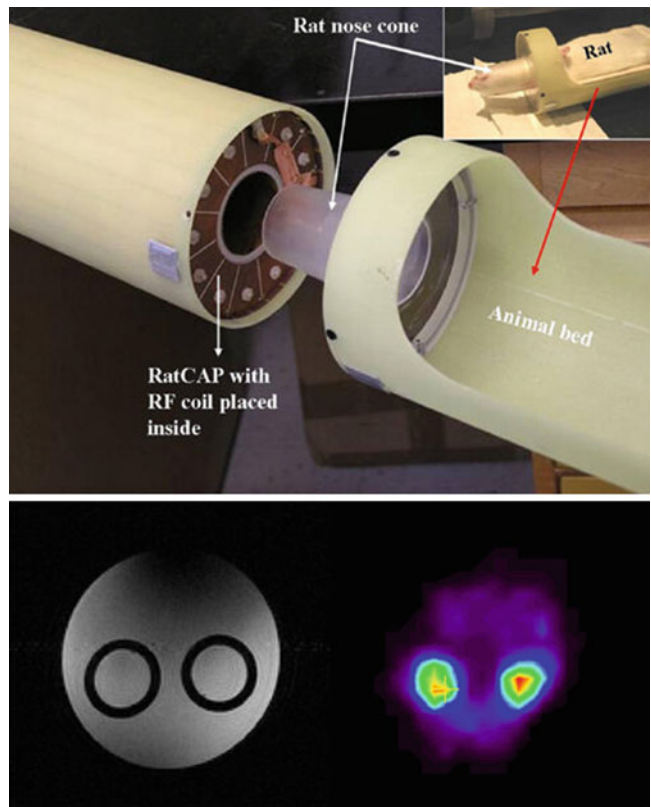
Simultaneously acquired PET/MR images using APD-based MRI-compatible PET insert (Reprinted from [32] with permission)
